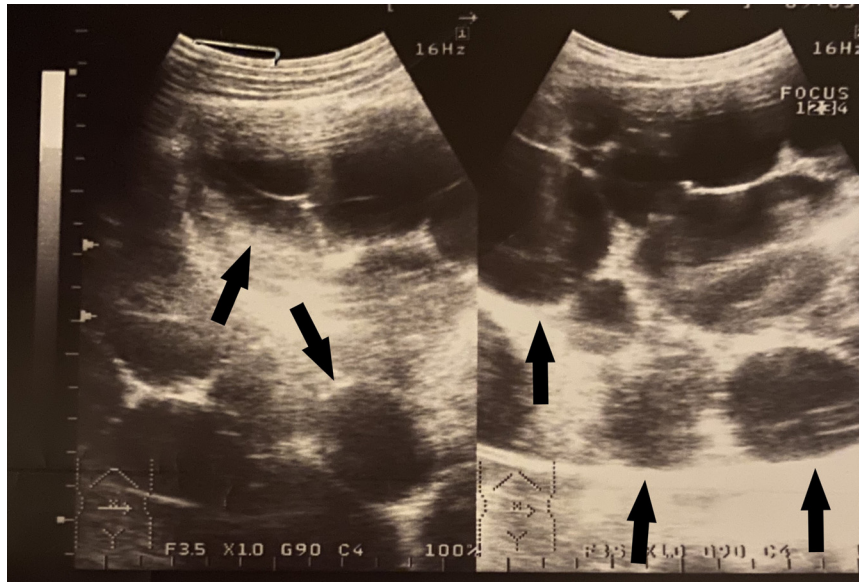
Abdominal ultrasound with cysts (arrows).
